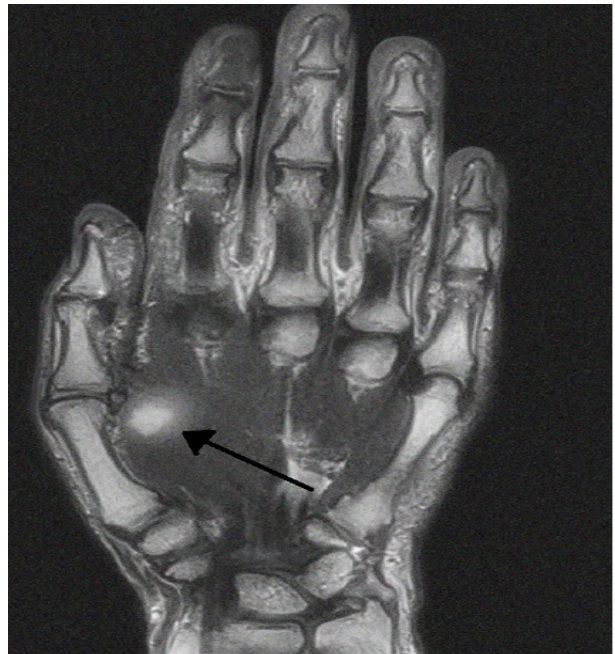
Hand MRI, T₁, sagittal cut. Black arrow shows a mass in the bulk of muscle.
